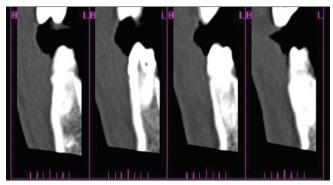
Spiral computed tomography scan (sagittal view) of right mandibular second premolar
